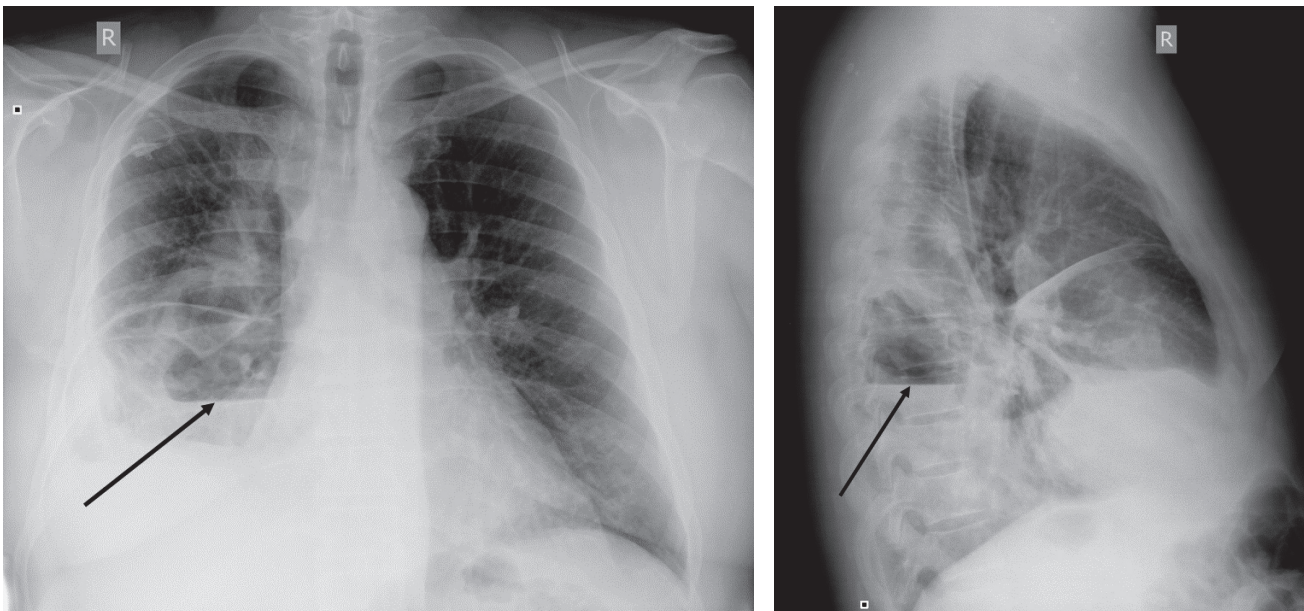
Chest X-ray on admission: the air–fluid level in the posterior aspect of the right chest
